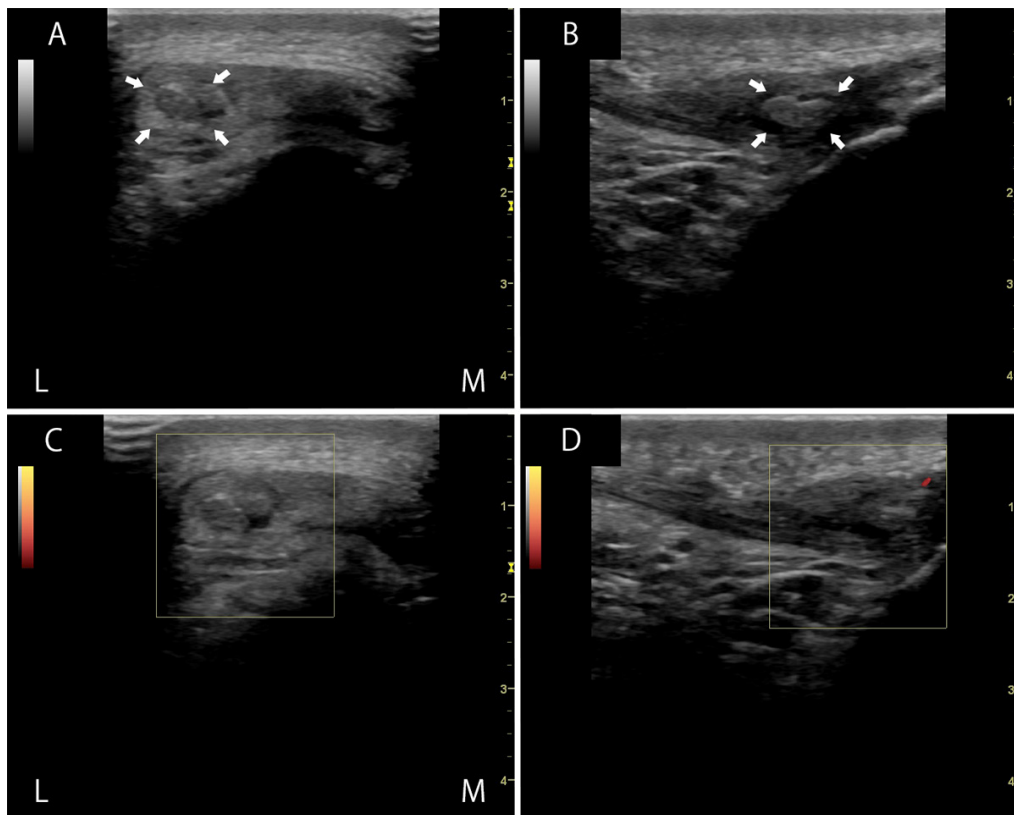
Lateral and short axis ultrasonography of the right patella tendon at 2 weeks. A and B: Hypoechogenic areas seen in the initial images have lessened in both short and long axes. The hyperechogenic areas (white arrows) represent organisation of a haematoma. C and D: Initial hypervascularity has also settled following a period of mobilisation.
